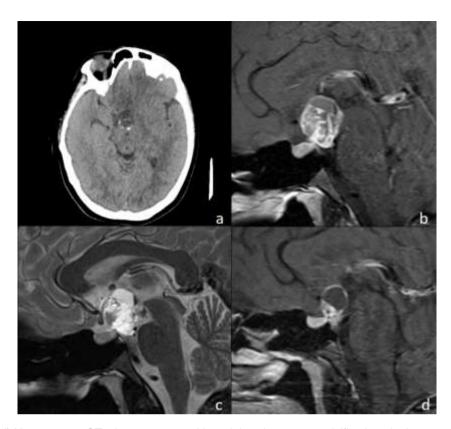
(a-d):Non-contrast CT shows a mass with peripheral punctate calcifications in the suprasellar area. (a). Solid lesion of stalk with cystic-necrotic component is shown on contrast enhanced T1-weighted sagittal image(b) and T2-weighted sagittal image(c). The mass copresses the optic chiasm from the posterior and causes visual symptoms(c). The remaining mass is demonstrated in the postop contrast-enhanced MR image taken two years after surgery(d).
